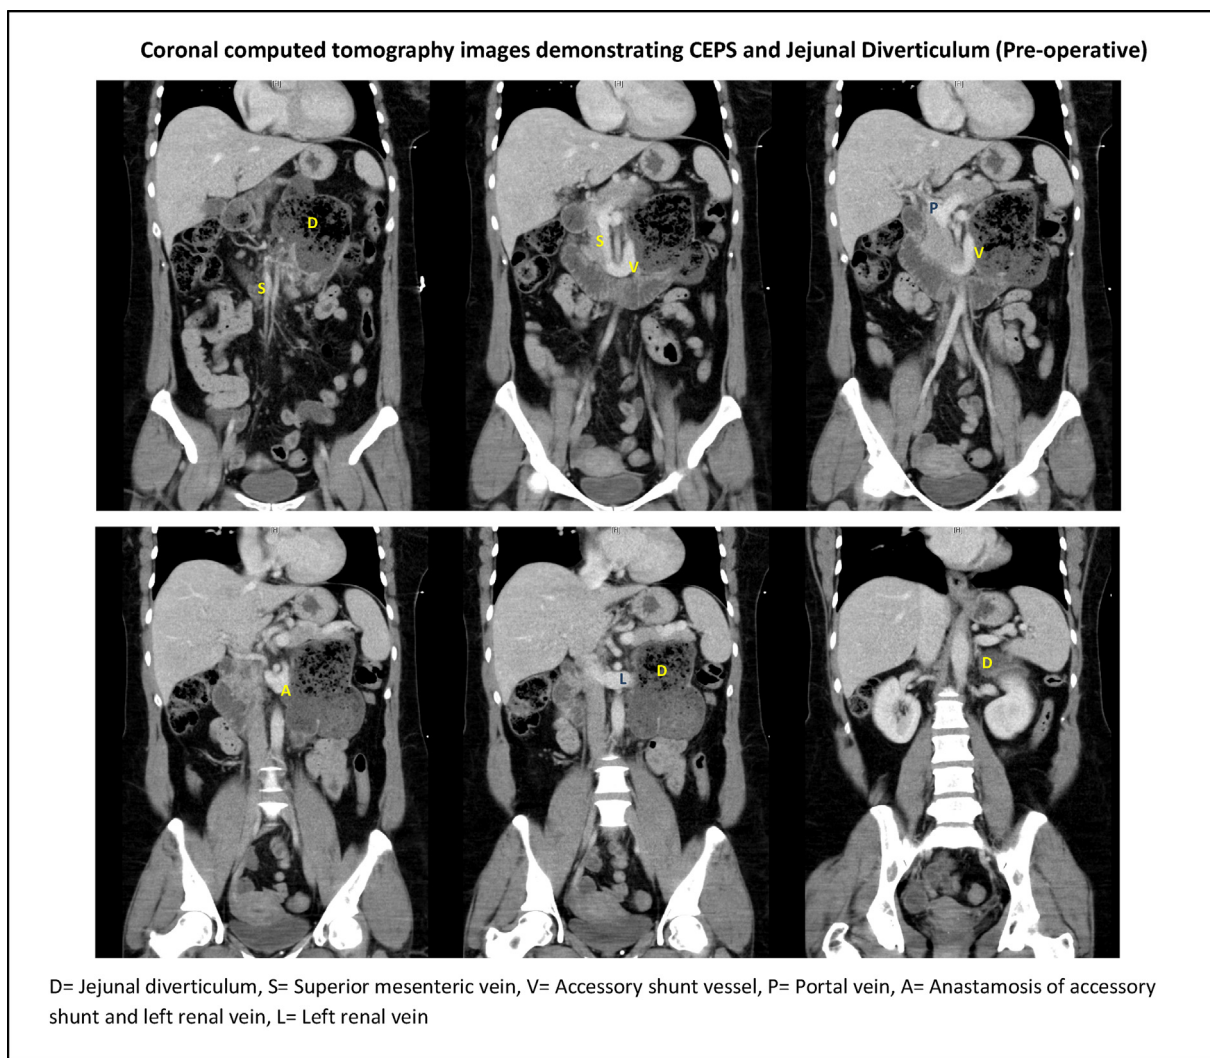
Coronal computed tomography images demonstrating CEPS and Jejunal Diverticulum (Pre-operative). D=Jejunal diverticulum, S=Superior mesenteric vein, V= Accessory shunt vessel, P= Portal vein, A= Anastomosis of accessory shunt and left renal vein, L= Left renal vein
